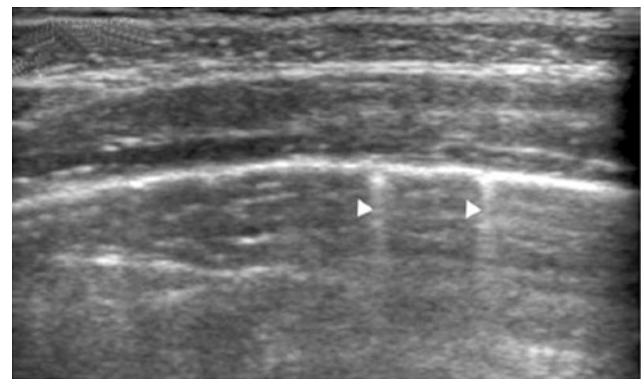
Premature infant with bronchopulmonary dysplasia. a Longitudinal US scan shows abundant B lines adjacent to the diaphragm. b Corresponding CT scan clearly shows thickening of the interlobular septa, the cause of the B lines on US
